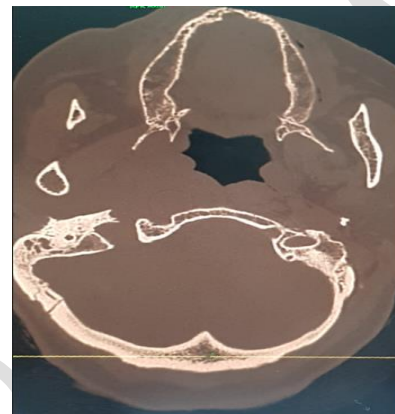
CT image showing the enlargement and filling of the jugular foramen and the Lacerum foramen
